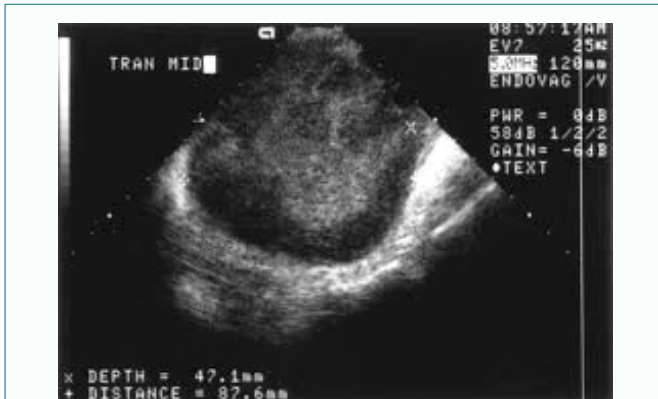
Ultrasonogram of the uterus showing fibroid.
